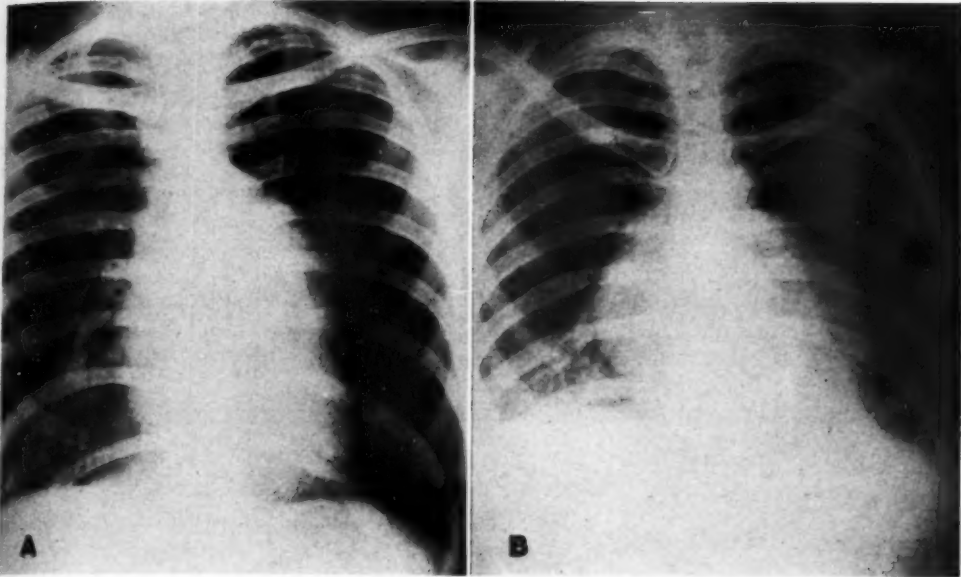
Roentgenograms taken Aug. 22, 1938, in inspiration (A) and expiration (B).
